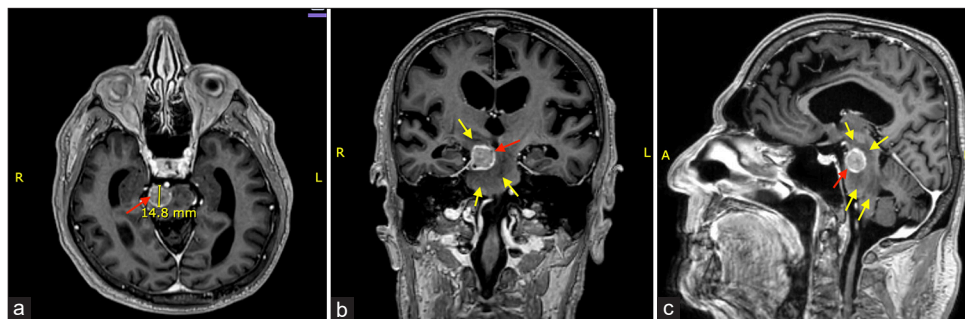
T1-weighted magnetic resonance imaging of the brain with gadolinium (a: axial; b: coronal; c: sagittal) showing a $1.6 \times 1.7 \times 1.8$ cm enhancing lesion (red arrows) in the right anterior aspect of the pons, extending superiorly to the midbrain and cerebral peduncle, with small cystic components measuring up to 4 mm and predominant rim enhancement, significant surrounding edema (yellow arrows) in the brainstem extending to the right superior, middle cerebellar peduncles and right cerebellum, and superiorly to the right thalamus and posterior limb of the right internal capsule, with no other focus of abnormal enhancement in the brain, midline shift or herniation.
